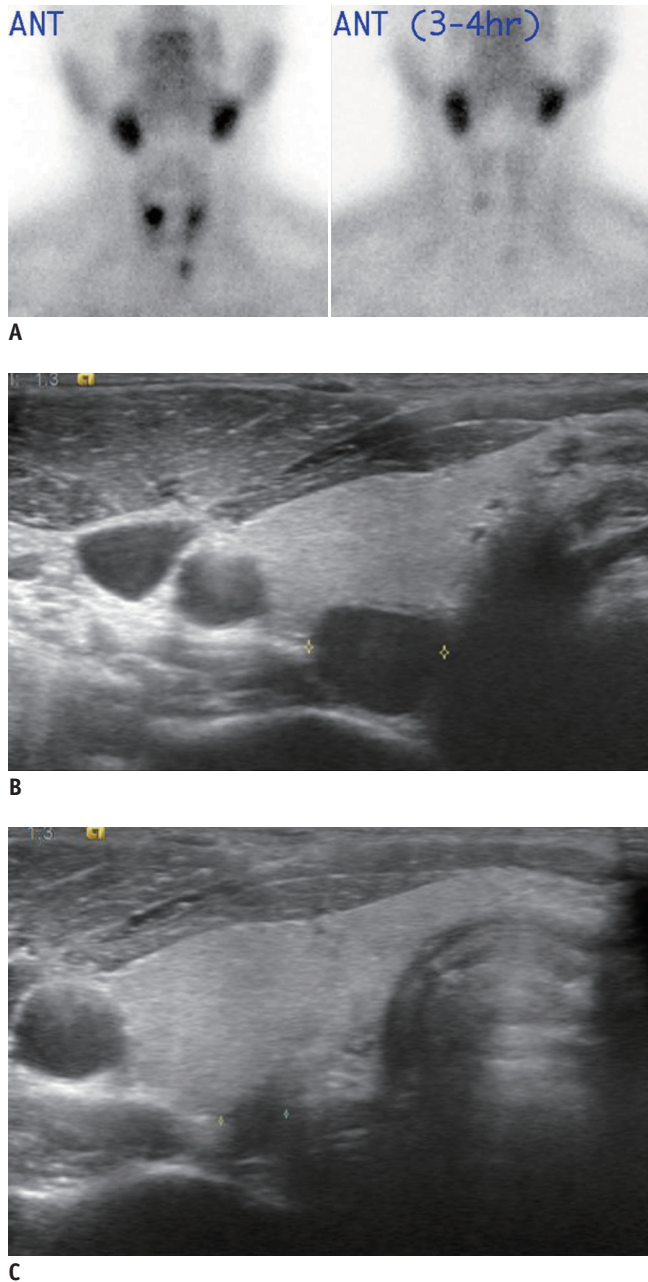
A 32-year-old male with secondary hyperparathyroidism. A, B. Technetium-sestamibi scan and US examination revealed three parathyroid hyperplasias (sonographic image of left hyperplasia is not presented here). C. After ablation of three lesions with hyperplasia, serum PTH and calcium levels were within target range (serum PTH, 1043 pg/mL → 1008 pg/mL → 251.3 pg/mL; calcium, 9.5 mg/dL → 8.9 mg/dL → 8.8 mg/dL at 9 months after initial treatment). However, new small parathyroid lesion was detected in right lower aspect, and serum PTH level tended to increase again during the follow-up (serum PTH, 435 pg/mL; calcium, 9.7 mg/dL at 18 months after initial treatment).
